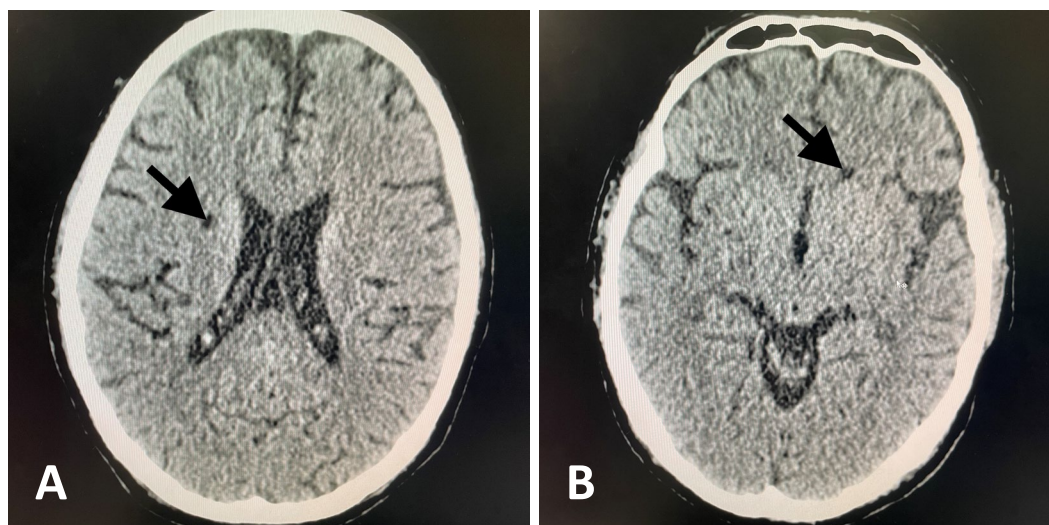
Cranial computed tomography scan showed old infarcts in the right corona radiata (A) and lentiform nucleus (B).
